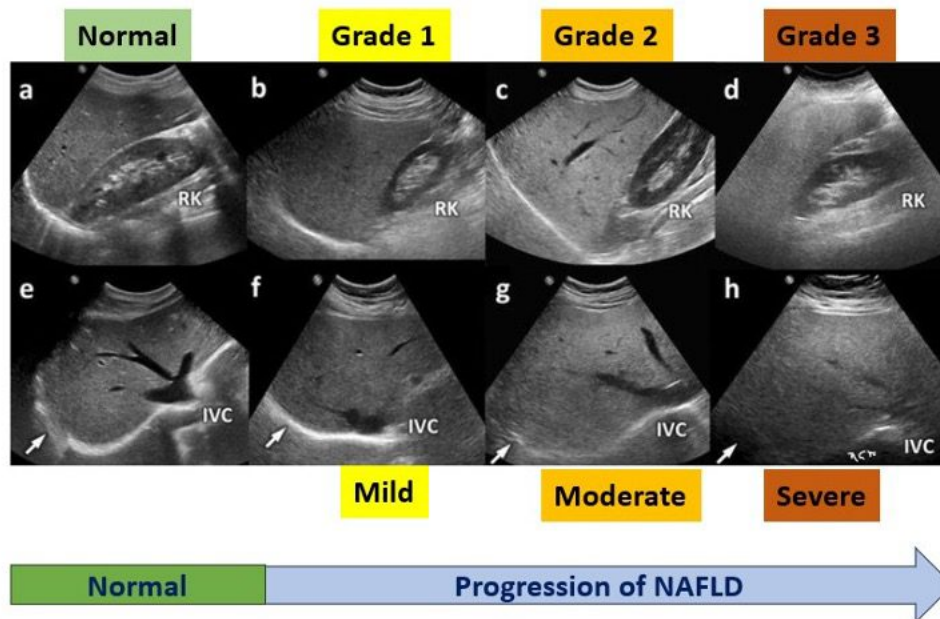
Ultrasound appearance of non-alcoholic fatty liver disease (NAFLD): diffuse increase in parenchymal echogenicity with posterior attenuation of the ultrasound beam.*
